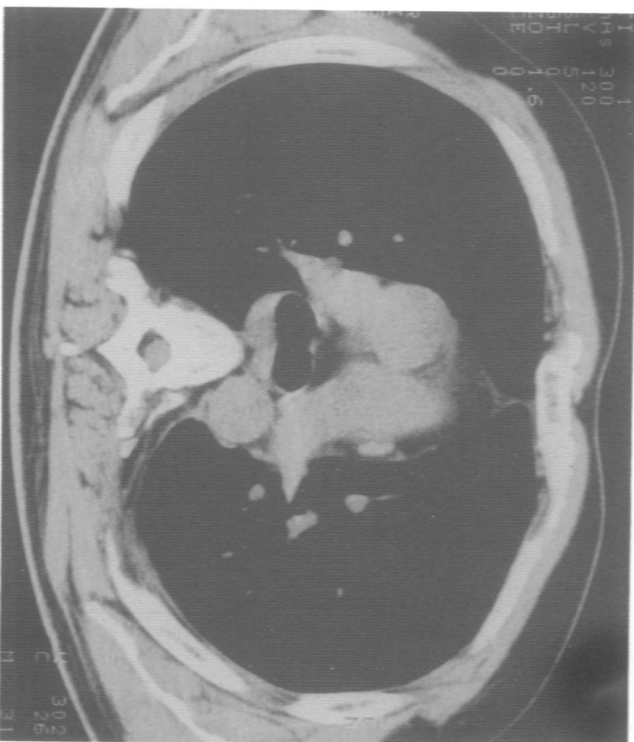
Partial reponse of pleural mesothelioma (evaluable disease) and a mediastinal lymph node (measurable disease) metastasis in the left hemithorax. (a) Pretreatment CT scan. (b) After two cycles of IL-2.
